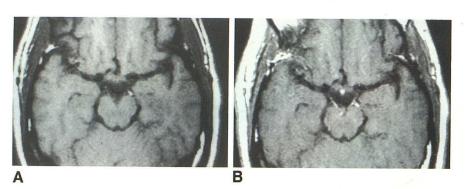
Case 6; 49-year-old HIV positive man with an inflammatory polyneuropathy resulting in diffuse arm and leg weakness and a right facial weakness. No diplopia. Pre-(A) and postcontrast (B) T1-weighted (600/20) axial MR demonstrates enhancement of the third cranial nerves. Enhancement of the right seventh cranial nerve in the temporal bone was also demonstrated on the lower sections.
